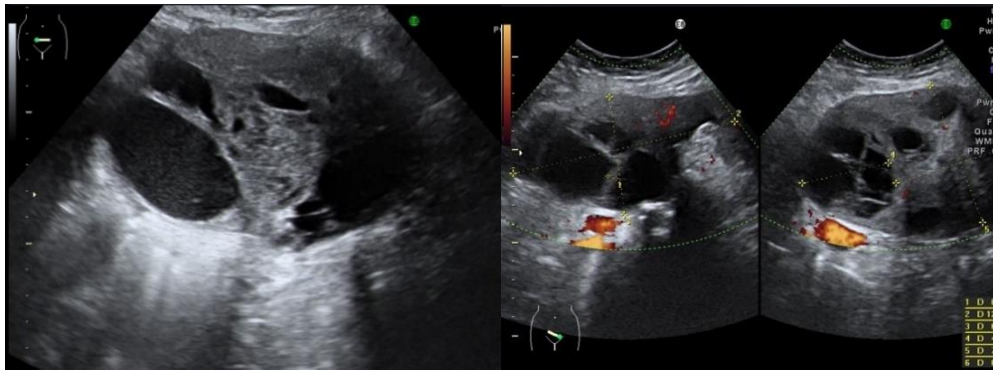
Atypical uterine cystic-solid leiomyosarcoma mimicking fibroid with mixed echostructure on gray-scale imaging (A) and at color Doppler blood flow mapping (B)
